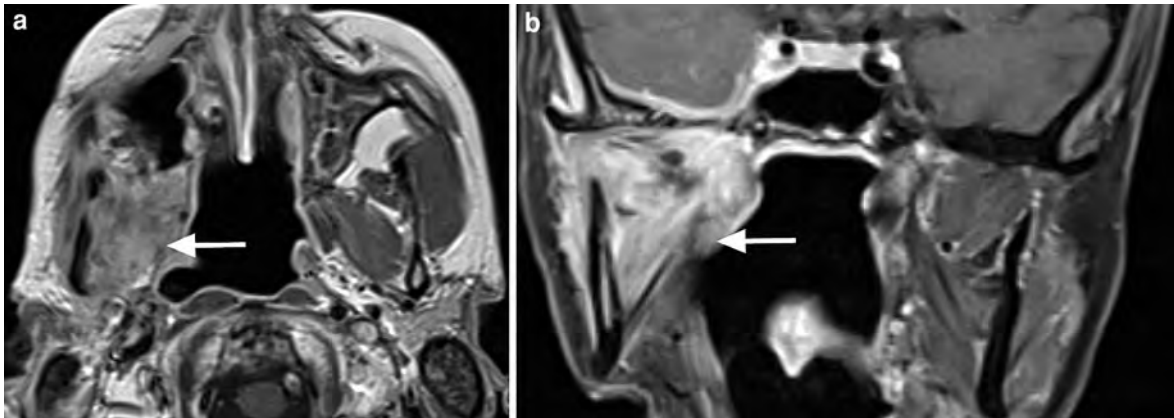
Malignant extrinsic lesion of the right masticator space in a 49-year-old female with numbness and pain of the right V3 territory with recurrent perineural tumor spread by an adenoid cystic carcinoma of the parotid gland. a Axial contrast-enhanced T1-weighted MR image shows a mass (*arrow*) primarily originating from the right parotid gland infiltrating
